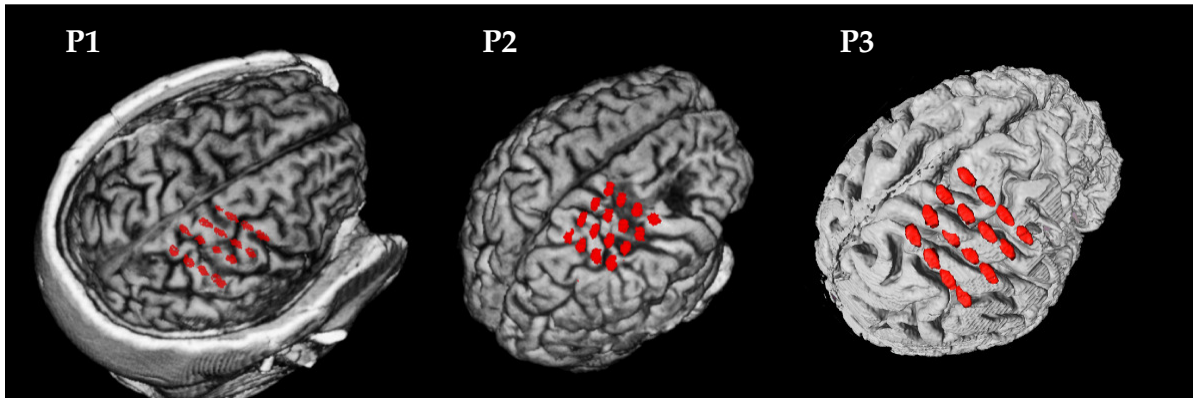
ECoG electrode positions from overlay of MRI and post-surgical CT for the three patients. From left to right: P1-P3. From Walter et al. [172]
